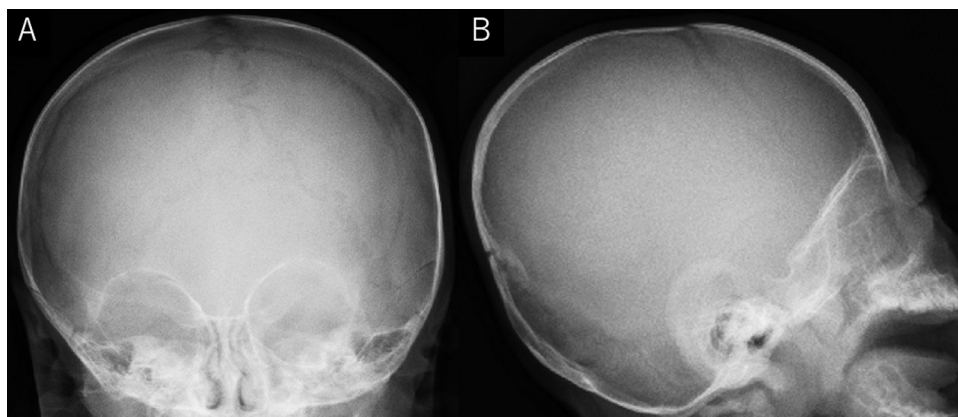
Cranial radiography, anteroposterior (A), and left-right lateral (B) views, showing an intact skull without fracture or deformation.
